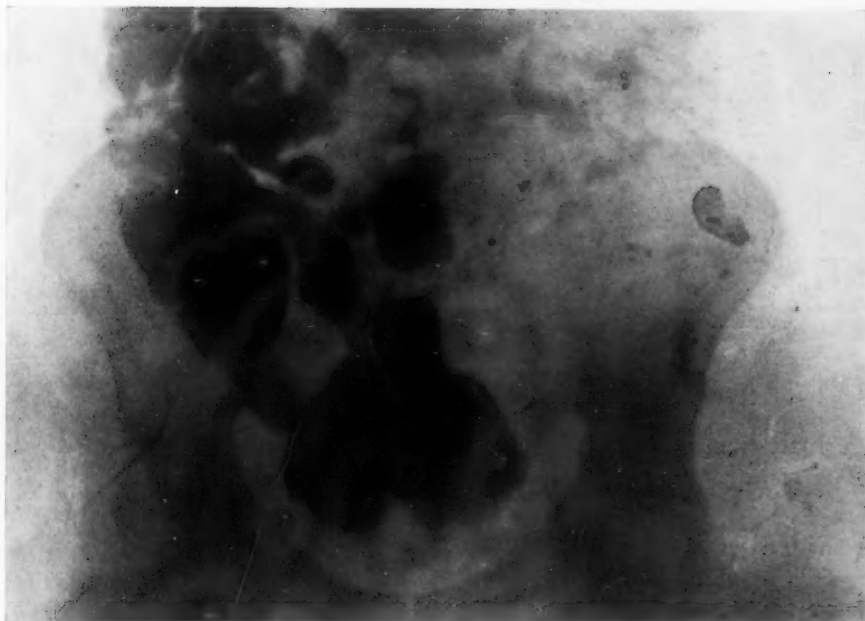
Case XII. Plate 7. Radiograph taken nine hours after bismuth meal, showing ileal stasis and puddling. At operation Lane's kink. Ileopelvic band attached at the point marked X.
